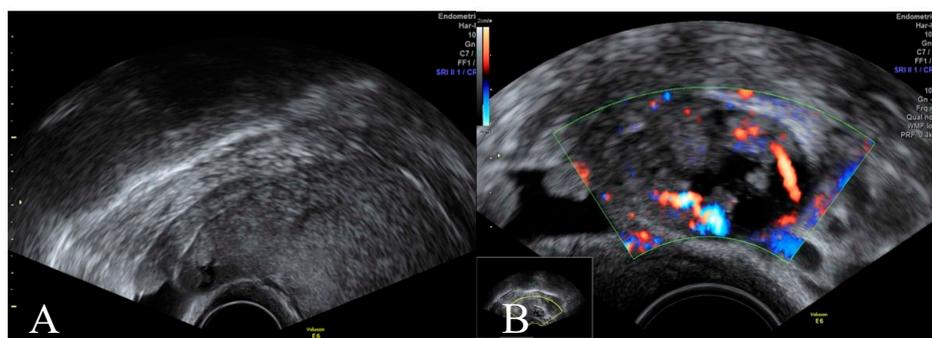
Pelvic ultrasound (PU) at the first consultation. Uterine mass suggestive for leiomyoma, reaching from the left lateral wall to the fundus (A). Doppler ultrasound shows a highly vascularized cystic, papillary structure attached to the mass (B).
